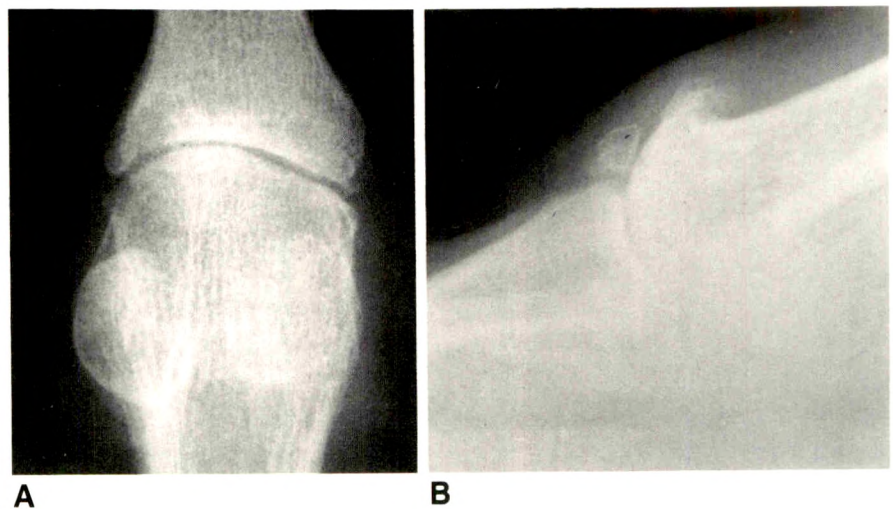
Value of erect lateral radiograph.
